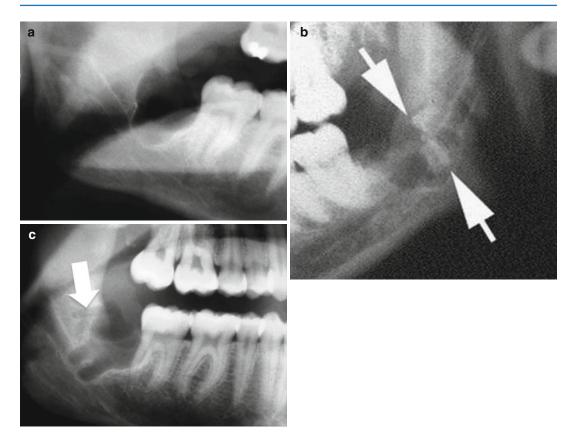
(a) Panoramic radiograph post-extraction, showing evidence the presence of radiographic predictors of potential IAN injury. (b) Panoramic radiograph showing retained root tips following third molar extraction
